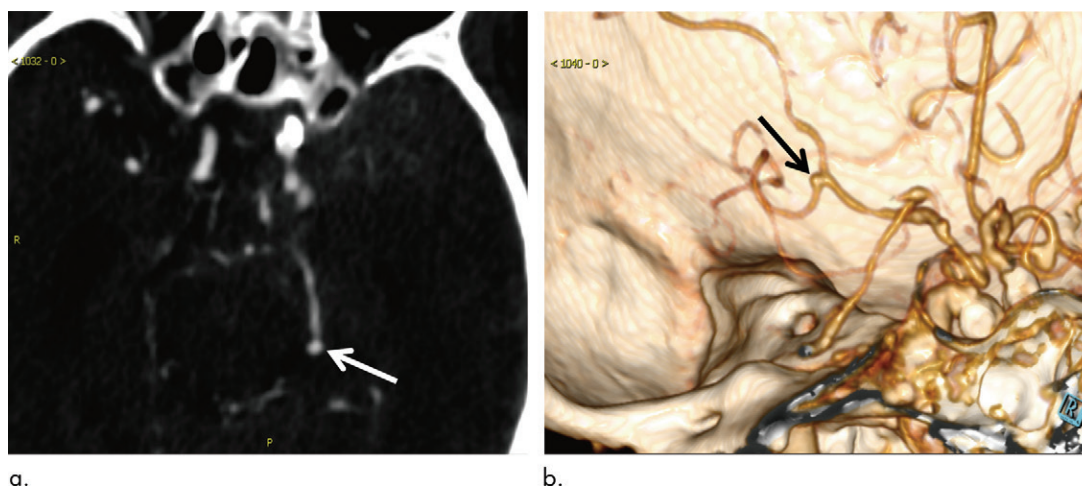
Images in 93-year-old woman with aneurysm 2 mm in maximum diameter located on left posterior cerebral artery (arrow). (a) Axial section head CT angiogram and (b) volume-rendered three-dimensional reconstruction image. Aneurysm was missed on initial report but was successfully detected with algorithm.
